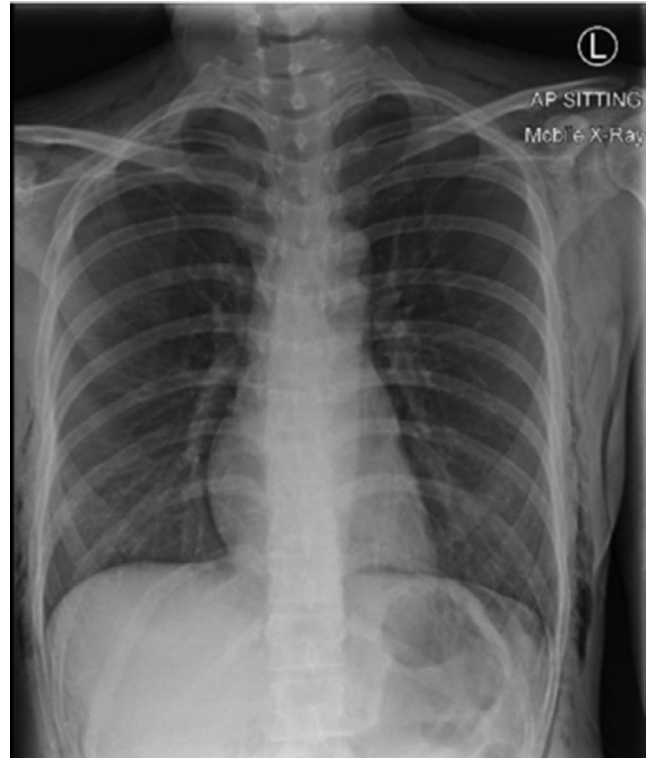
Chest X-ray done 8 hours postoperatively
